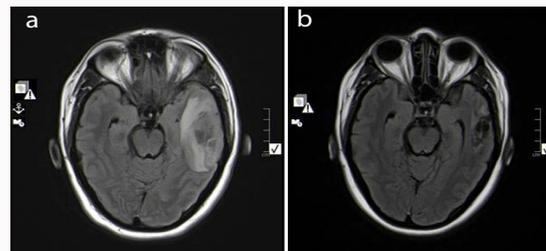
(a) Initial MRI demonstrates edema and hemorrhage in the left temporal lobe. (b) Follow up MRI 10 months later demonstrates encephalomalacia of left temporal lobe.
